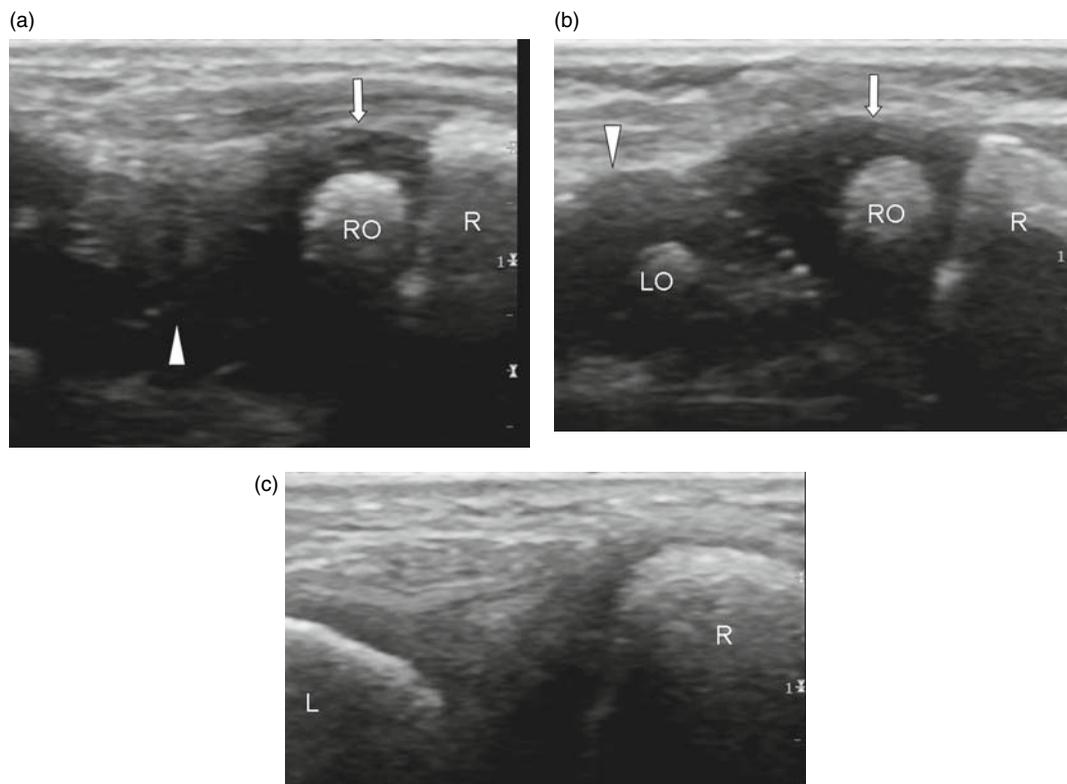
Cartilaginous centers prior to ossification are clearly visible on ultrasound as hypoechoic structures with early ossification beginning centrally as a zone of hyperechogenicity. (a) Longitudinal ultrasound of a 2-year-old girl demonstrating early ossification of the center distal radius (RO) surrounded by the hypoechoic cartilaginous center. No ossification has commenced within the lunate (arrowhead), which remains uniformly hypoechoic. (b) An early ossification center is now visible in the lunate (LO) in this 4-year-old boy. (c) Normal adult appearance.
